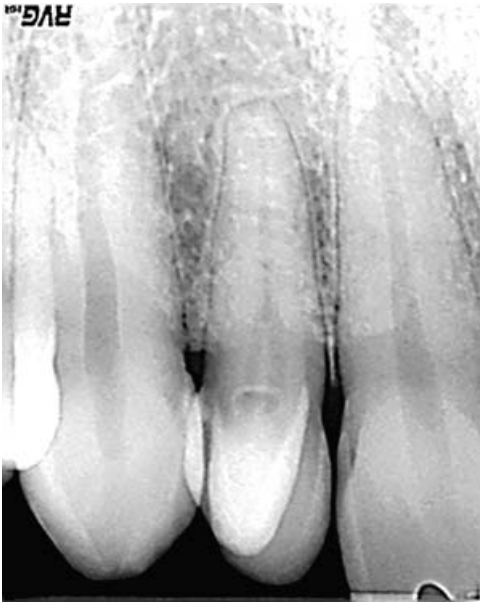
Periapical radiograph shows a V-shaped radiopacity extends from the CEJ to the incisal edge of upper right lateral incisor
